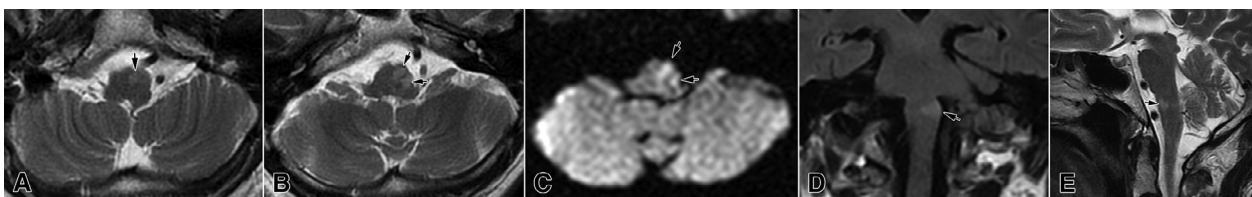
A left partial medial, anterolateral, and lateral infarction (arrows) of the upper medulla in the axial T2-weighted (A and B) and DWI (C) images, and in the coronal FLAIR (D) and sagittal T2-weighted (E) sections.
